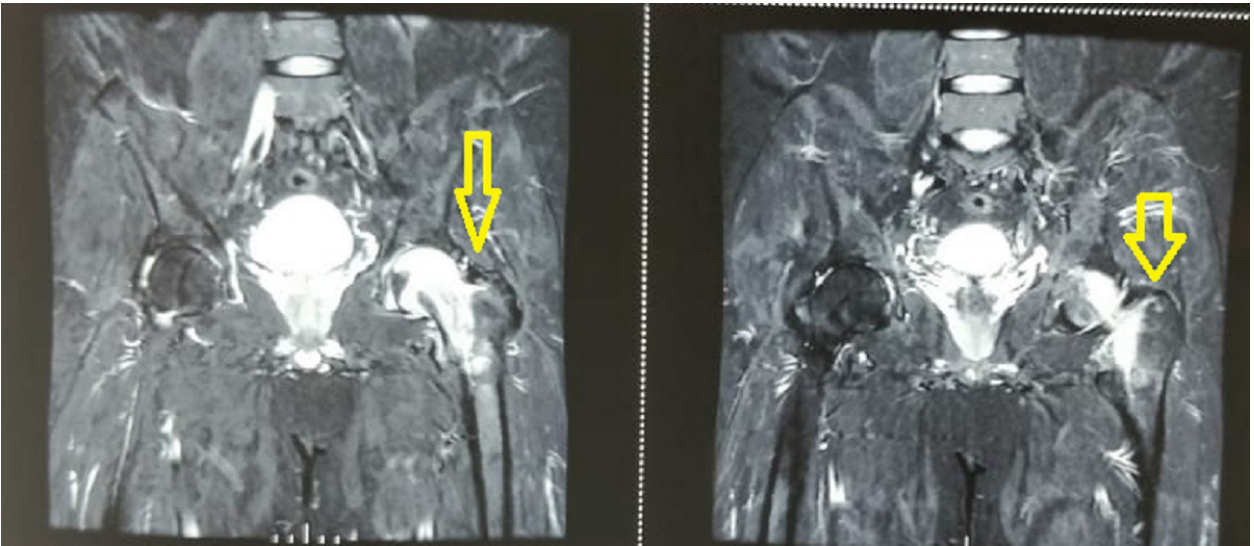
MRI Scan of the pelvis showing a hyperintense lesion in the head, neck, and trochanteric region of the left hip. There is no evidence of a subchondral fracture of the collapse of the femoral head
